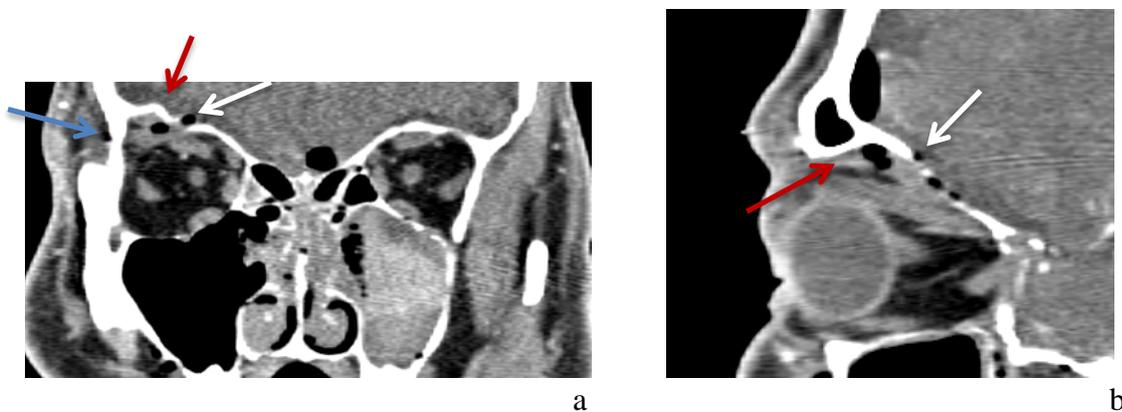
(a/b): Extraocular muscle dislocation (53-year-old male with a decreased elevation of the right eye). Unenhanced CT, coronal image (a): Fractures of right orbital roof (white arrow) and lateral wall (blue arrow) with an extraconal hemorrhage (red arrow) between frontal bone and right upper rectus muscle causes dislocation of the muscle. CT, sagittal section (b): Dislocation of right upper rectus muscle due to extraconal hemorrhage (red arrow) after orbital roof fracture (white arrow).
